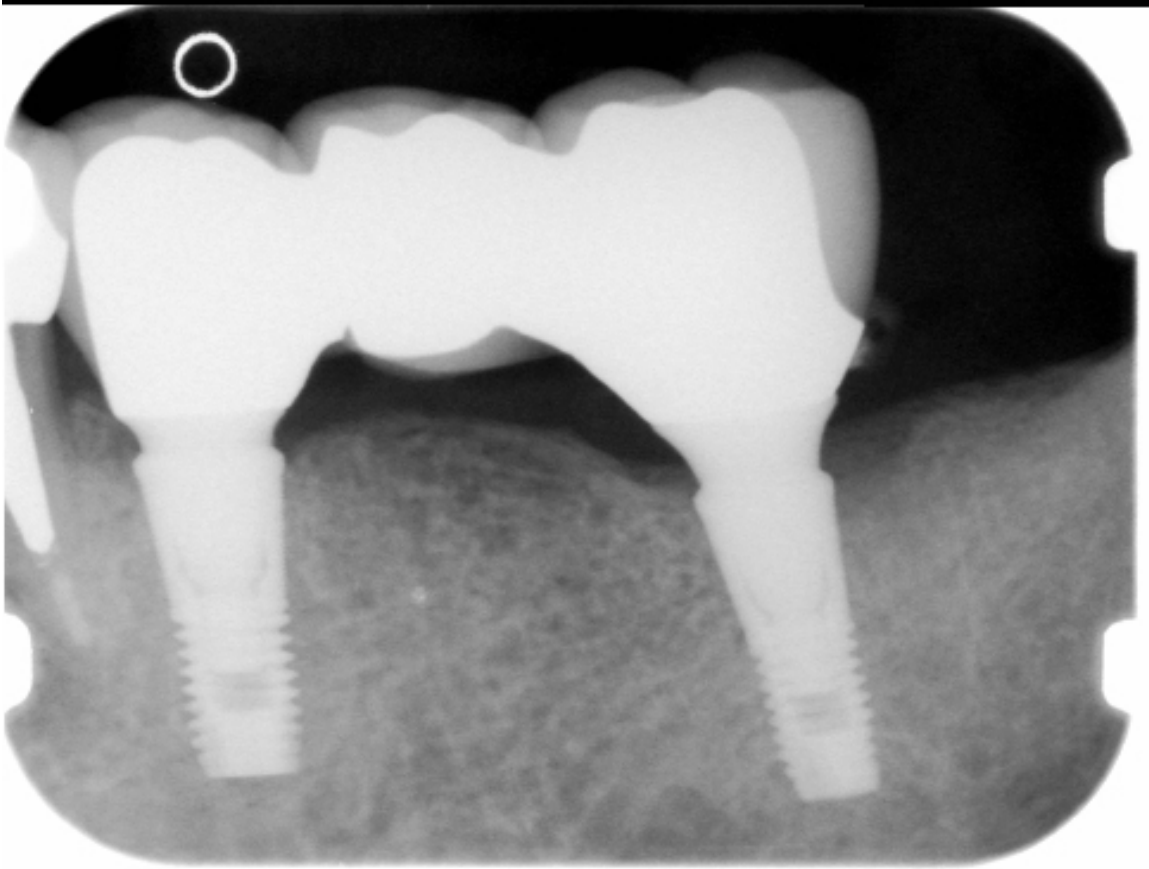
After failure of the tooth-borne FPD, two implants were placed in the position of tooth #20 and #18 with intention to support the FPD observed in this radiograph. The implants selected provide for the largest implant/abutment interface the selected system provided (AstraTech 4.5 mm implants) and utilized unitary abutment components of robust design (no separate abutment screw). The implant placement was properly organized in existing bone to limit bending moments acting at the implant/abutment interface.
